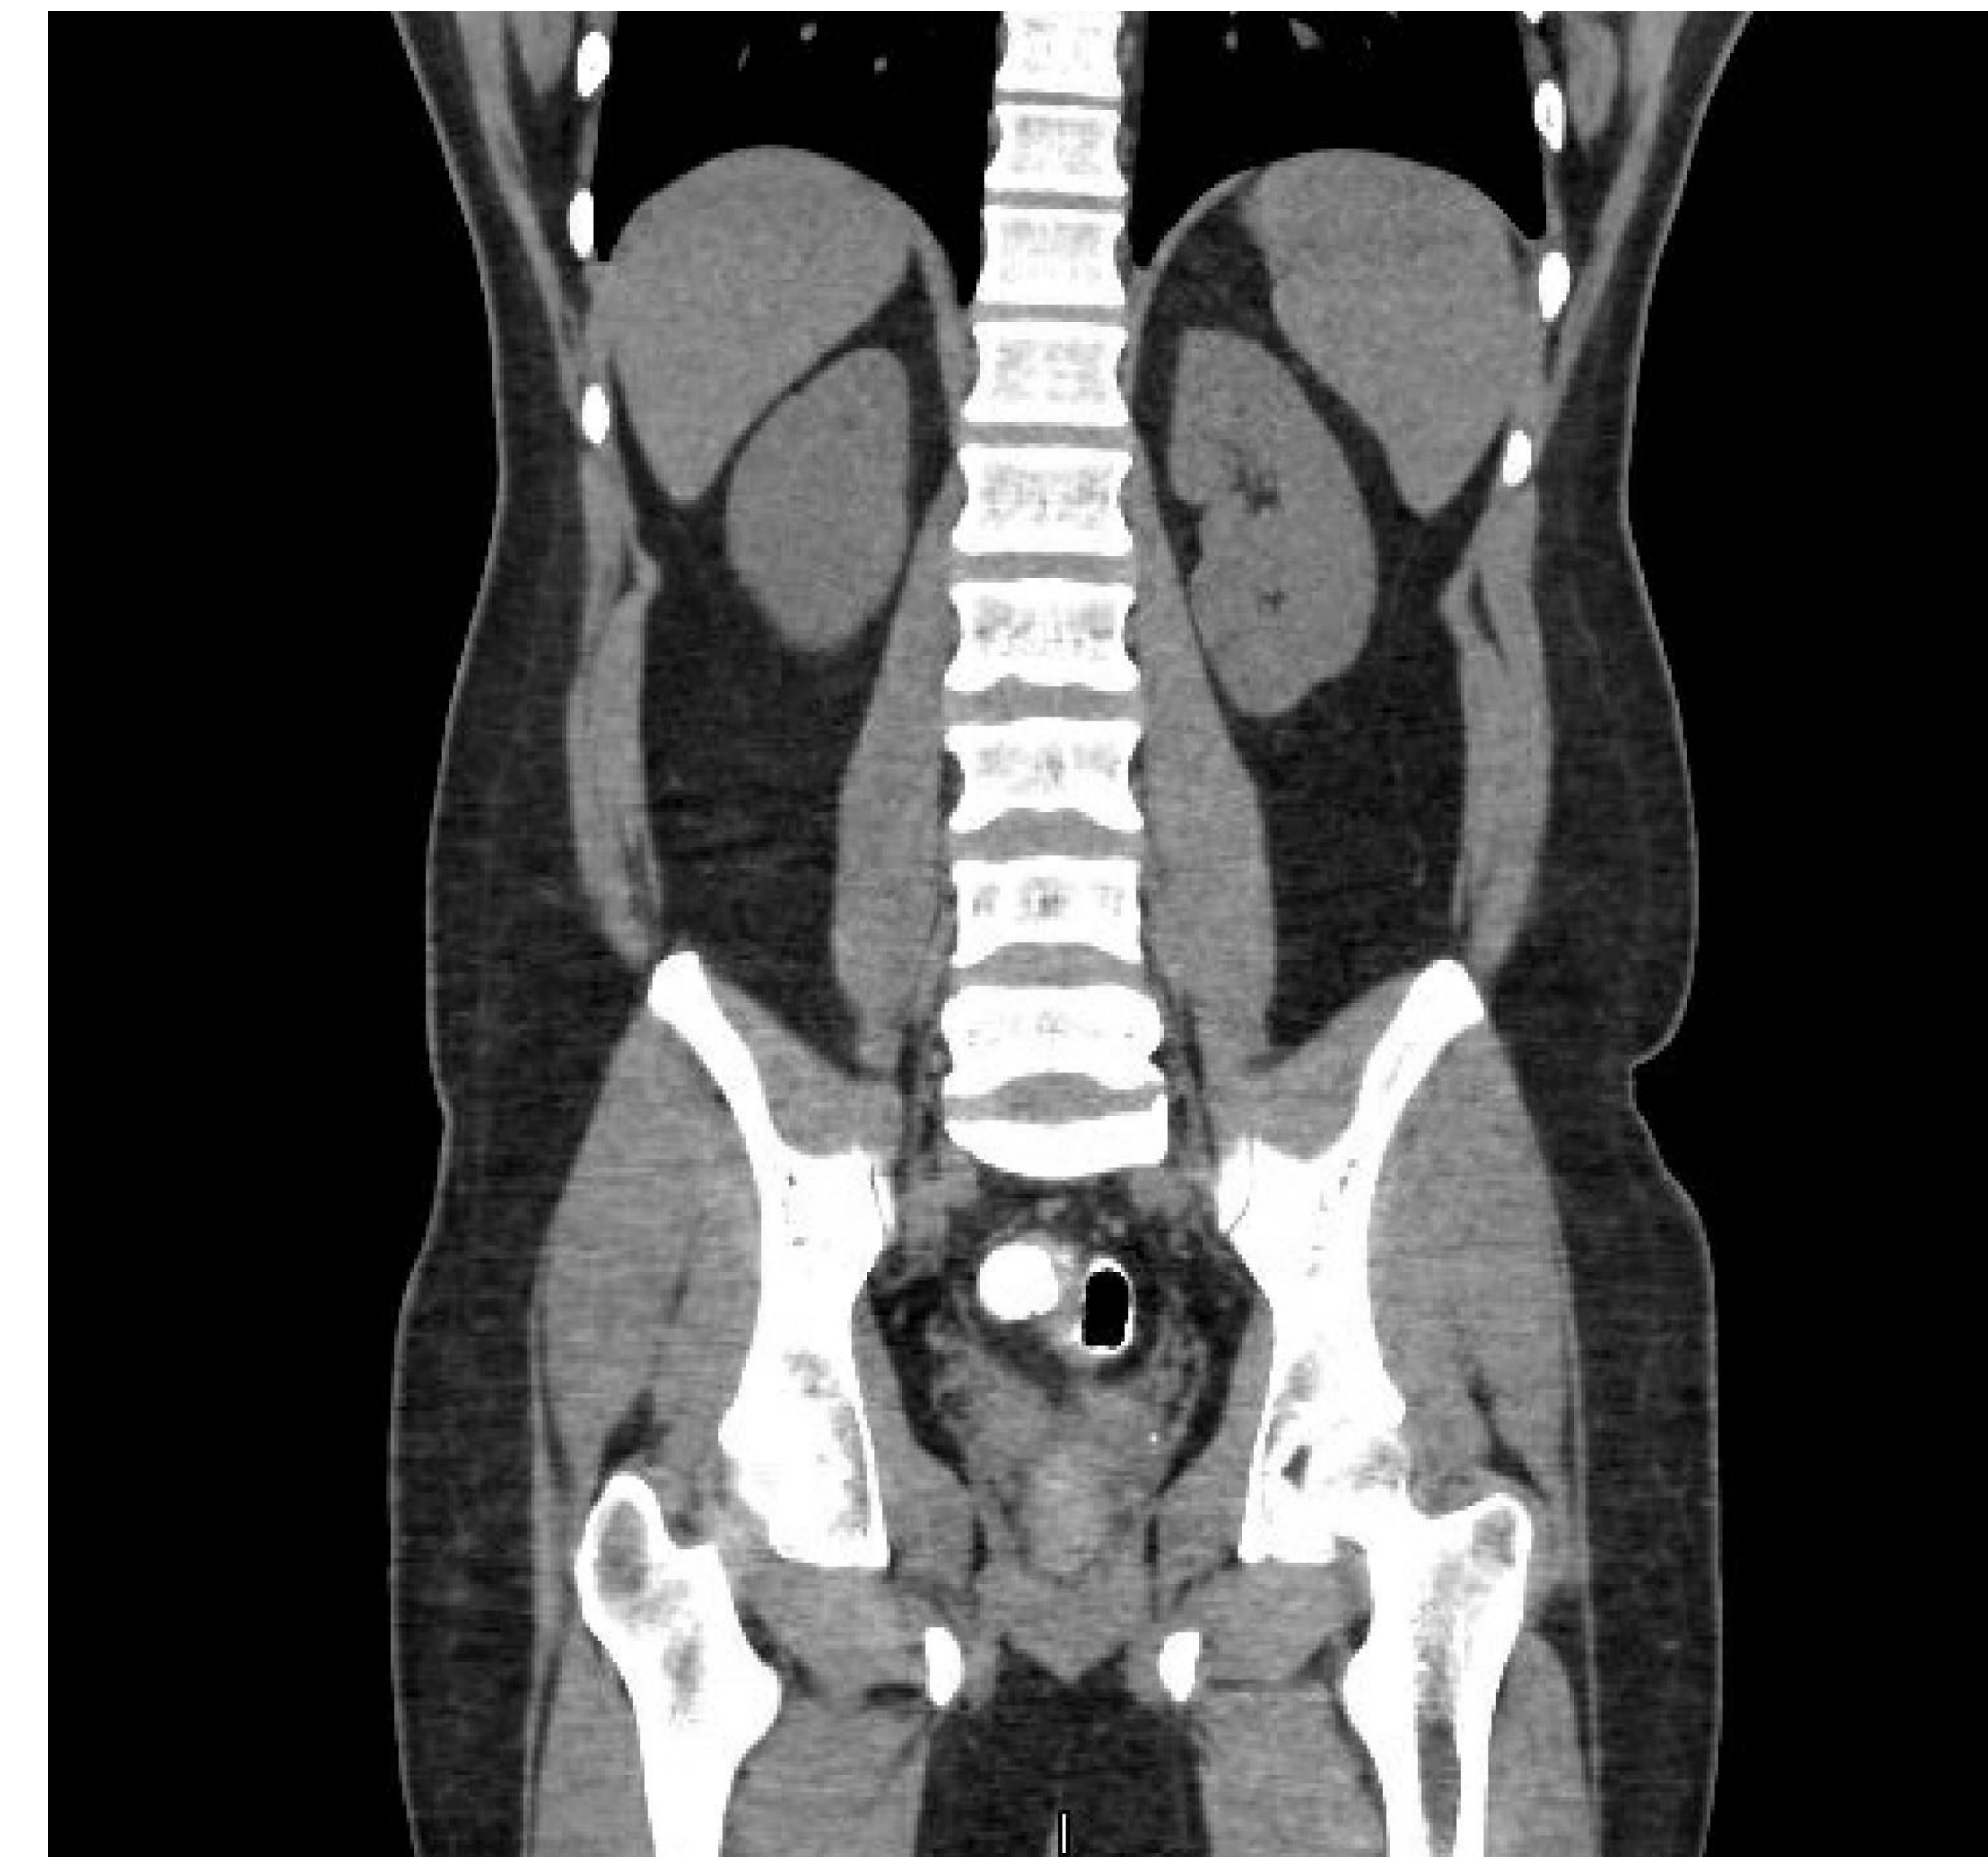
Colovesical Fistula as seen on CT.
